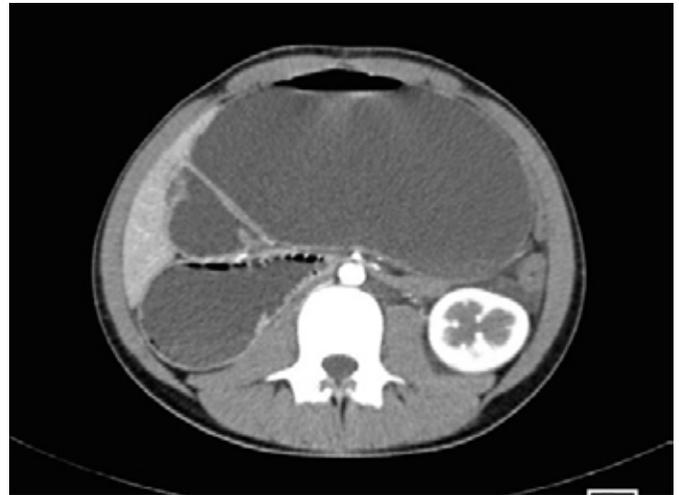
Axial abdominal CT showing gastric and duodenal dilation with duodenal compression point between aorta and superior mesenteric artery.
